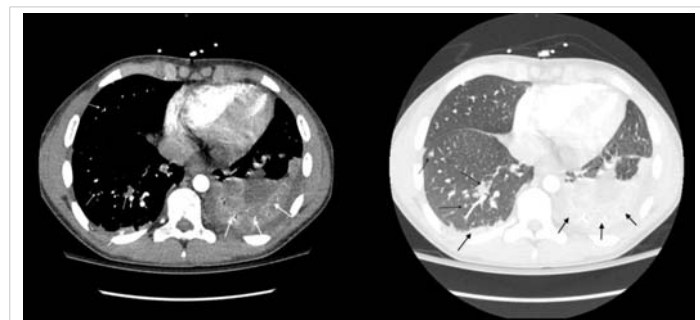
CT scan showing a small bilateral pleural effusion slightly larger on the left side with passive atelectasis of both pulmonary bases (thick arrows). Multiple bilateral nodular lesions, some of them cavitated, in relation to septic embolisms with an associated pulmonary infarction (thin arrows).
